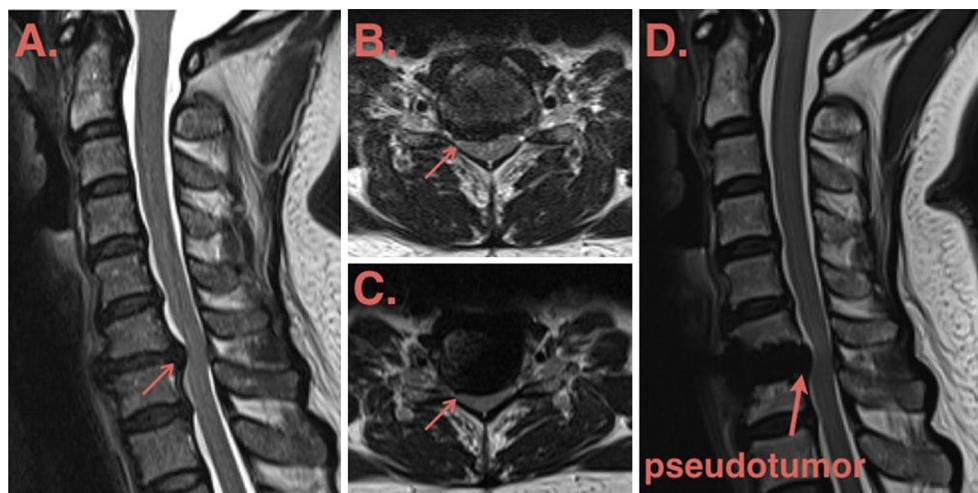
Cervical spine MRI, T2-weighted, before Bryan Disc implantation (a, b) and after traumatic loosening of Bryan Disc arthroplasty (c, d). a Sagittal view, arrow indicates herniated disc at C6–C7 level with diminished CSF space. b Coronal view, arrow shows protruded disc with predominant cord compression at right side. c Coronal
